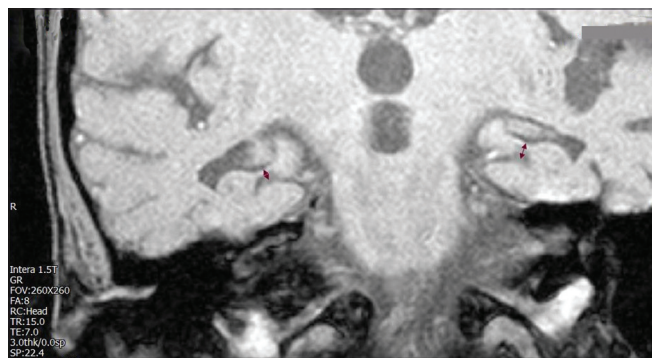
Fimbriosubicular distance as an indicator of HS width is a linear measurement perpendicular to the long axis of the temporal lobe in high-resolution coronal T1-weighted images
